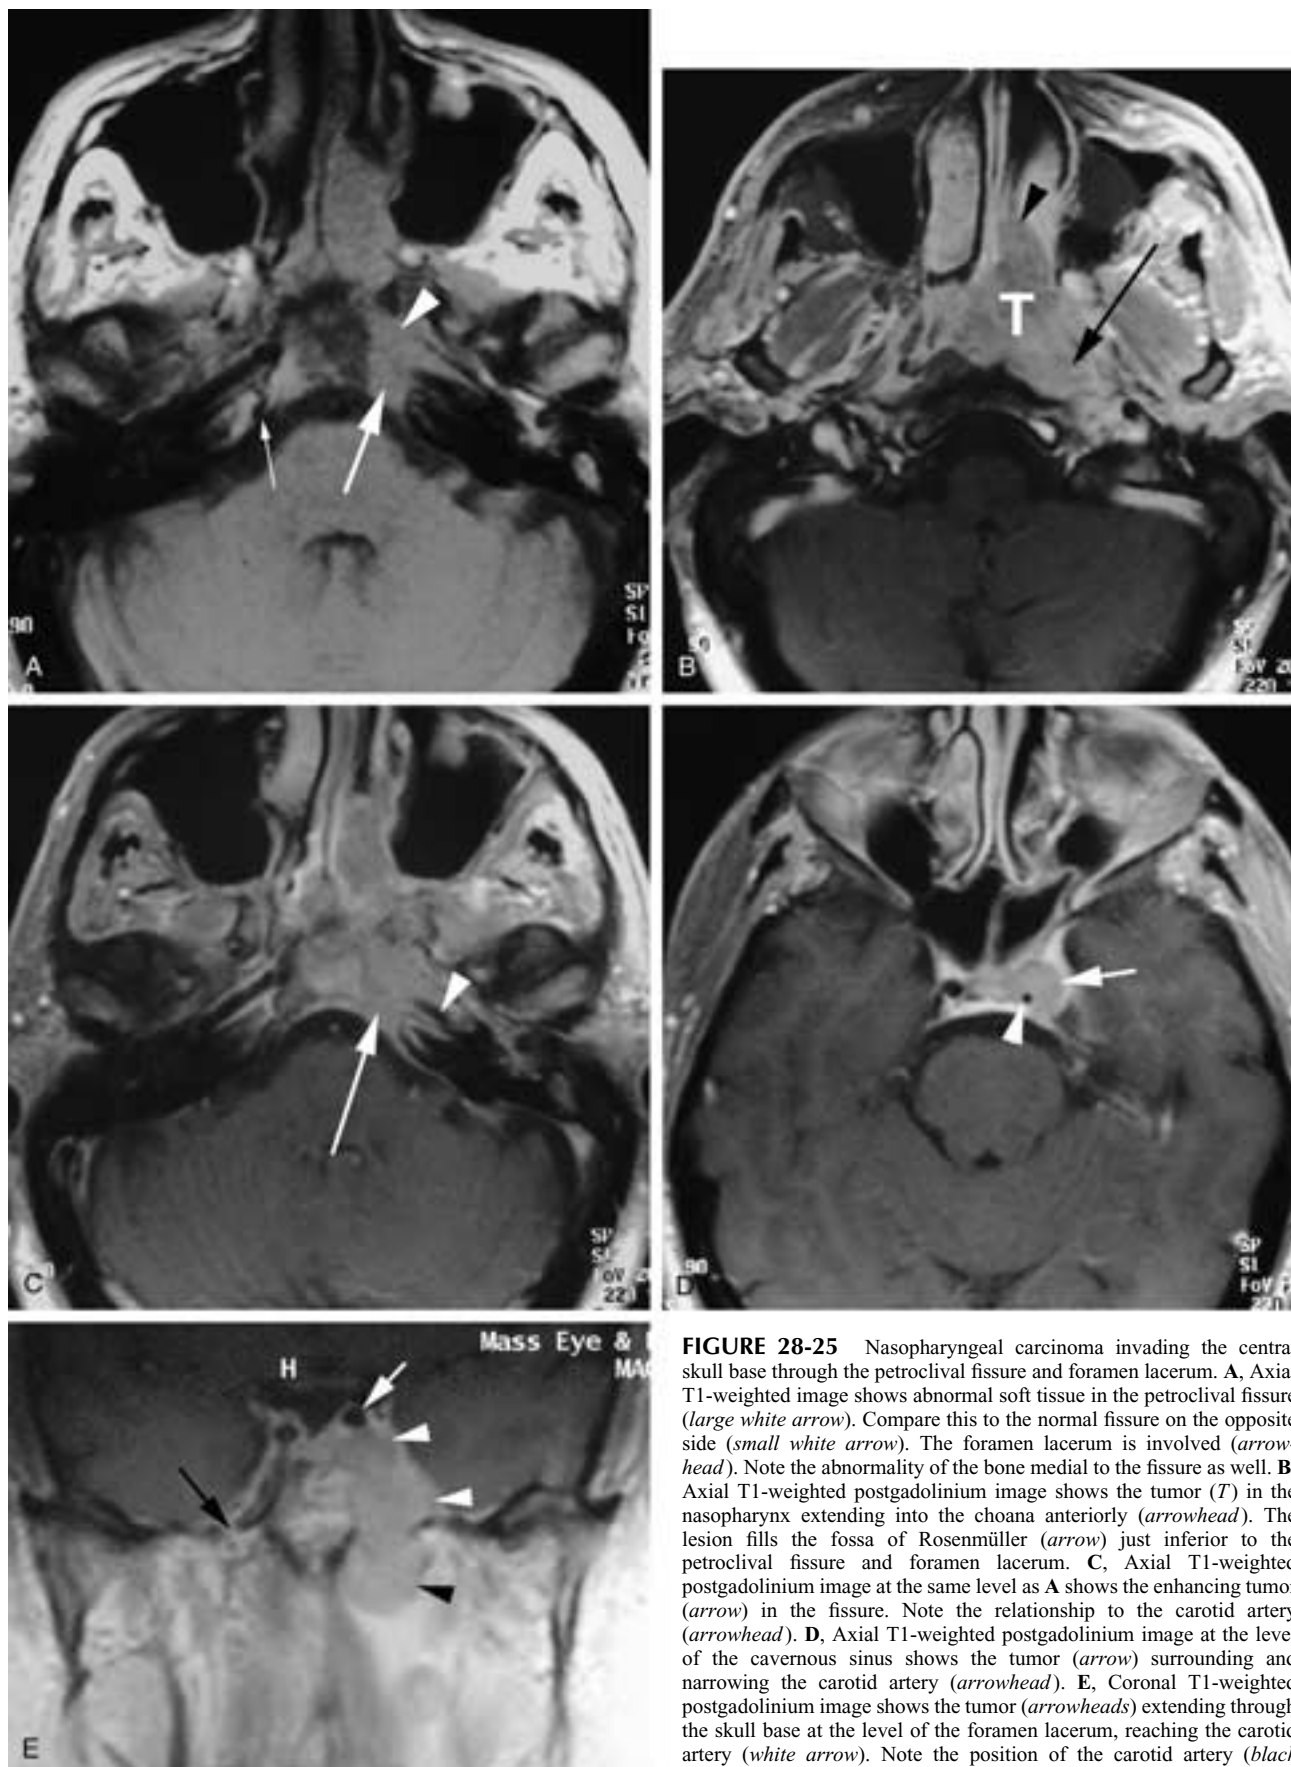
Nasopharyngeal carcinoma invading the central skull base through the petroclival fissure and foramen lacerum. A, Axial T1-weighted image shows abnormal soft tissue in the petroclival fissure (*large white arrow*). Compare this to the normal fissure on the opposite side (*small white arrow*). The foramen lacerum is involved (*arrowhead*). Note the abnormality of the bone medial to the fissure as well. B, Axial T1-weighted postgadolinium image shows the tumor (*T*) in the nasopharynx extending into the choana anteriorly (*arrowhead*). The lesion fills the fossa of Rosenmüller (*arrow*) just inferior to the petroclival fissure and foramen lacerum. C, Axial T1-weighted postgadolinium image at the same level as A shows the enhancing tumor (*arrow*) in the fissure. Note the relationship to the carotid artery (*arrowhead*). D, Axial T1-weighted postgadolinium image at the level of the cavernous sinus shows the tumor (*arrow*) surrounding and narrowing the carotid artery (*arrowhead*). E, Coronal T1-weighted postgadolinium image shows the tumor (*arrowheads*) extending through the skull base at the level of the foramen lacerum, reaching the carotid artery (*white arrow*). Note the position of the carotid artery (*black arrow*) on the opposite side just above the foramen lacerum.
